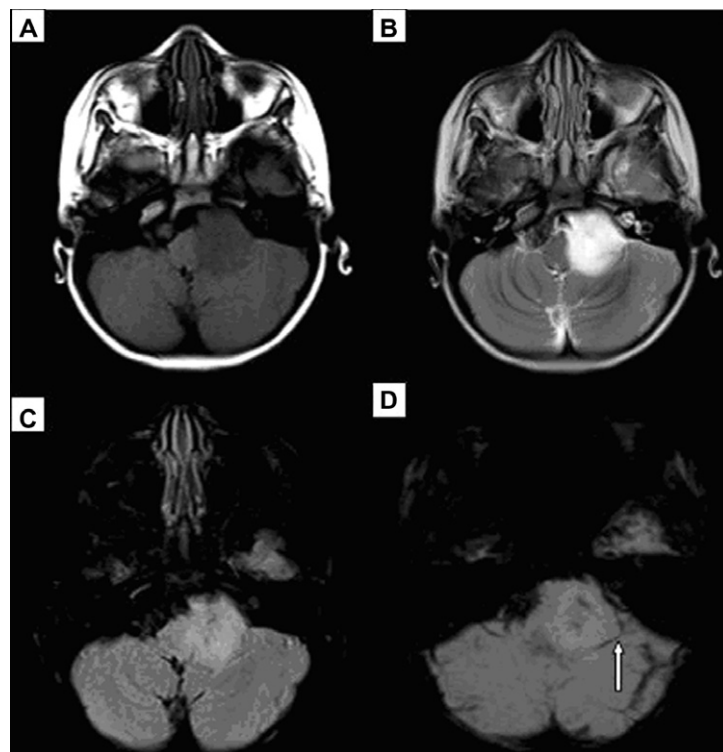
Three year old female patient presenting with bulbar symptoms. T1 (A), T2 (B) and FLAIR (C) images show left CPA angle lesion, SWI minIP (D) images reveals its extra-axial location by demonstrating a displaced vessel (arrow) between the mass and the cerebellum.
